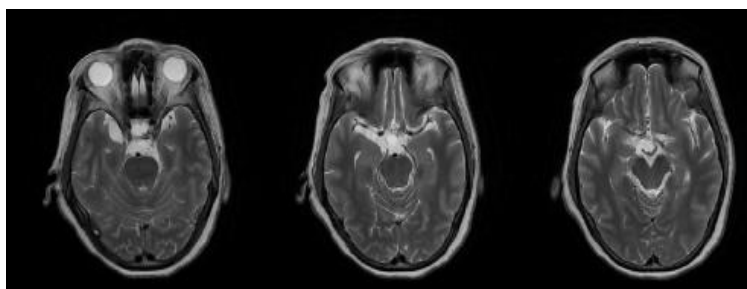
MRI imaging shows a supratentorial extra-axial lesion with a regular border in the right cisterna sylvii, interpeduncular cisterna, prepontine cisterna, and left crural cisterna at T2W1.
